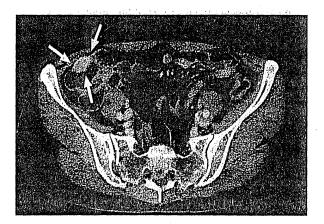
Abdominal contrast CT depicts a well-demarcated, semi-round tumor (white arrows) with relatively homogeneous enhancement.
